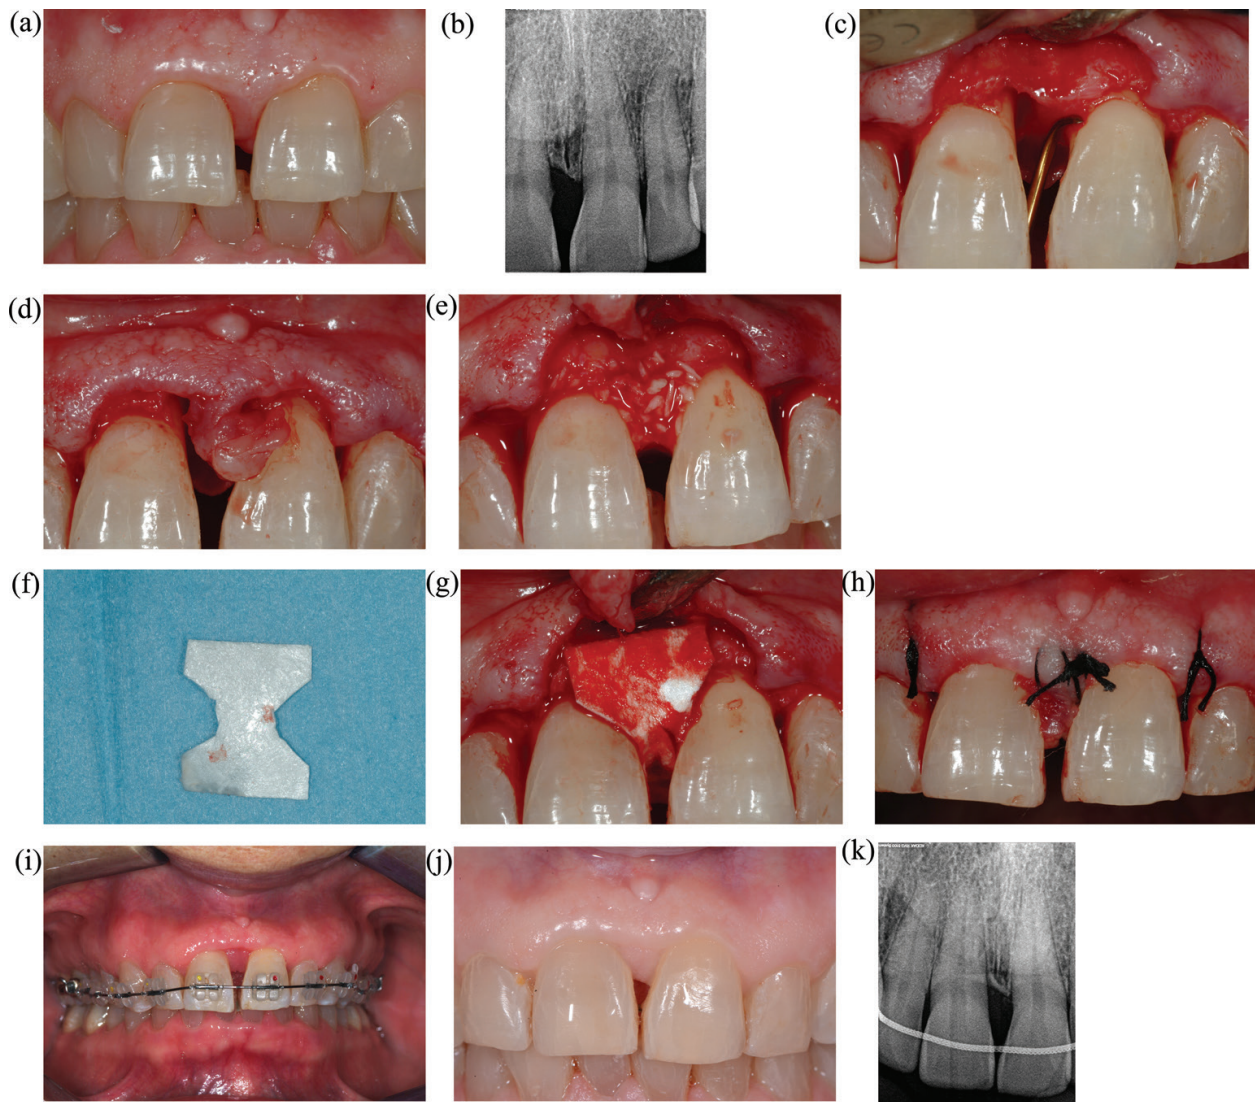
Thirty-eight-year-old female patient (T.A.), whose midline diastema was opened during the past 3 years. Major request was diastema closure. (a) Initial intraoral aspect; (b) initial radiograph; (c) deep manual debridement during surgical intervention. A supragingival debridement was previously performed; (d) sufficient gingival tissue for appropriate coverage of regenerative materials; (e) synthetic bone grafting; (f) membrane shaped extraorally following the area to be covered; (g) adaptation of the membrane in order to cover all grafting material; (h) suturing with coronal flap adaptation; (i) orthodontic treatment started 3 months after surgery; (j) clinical aspect at the end of orthodontic treatment; (k) radiograph at the end of orthodontic treatment with lingual fixed retainer.
